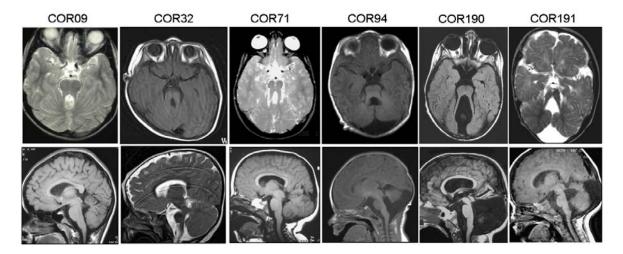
Axial (upper lane) and median sagittal (lower lane) brain MRI sections of six probands showing the typical "molar tooth sign" and associated CNS malformations (see text).
